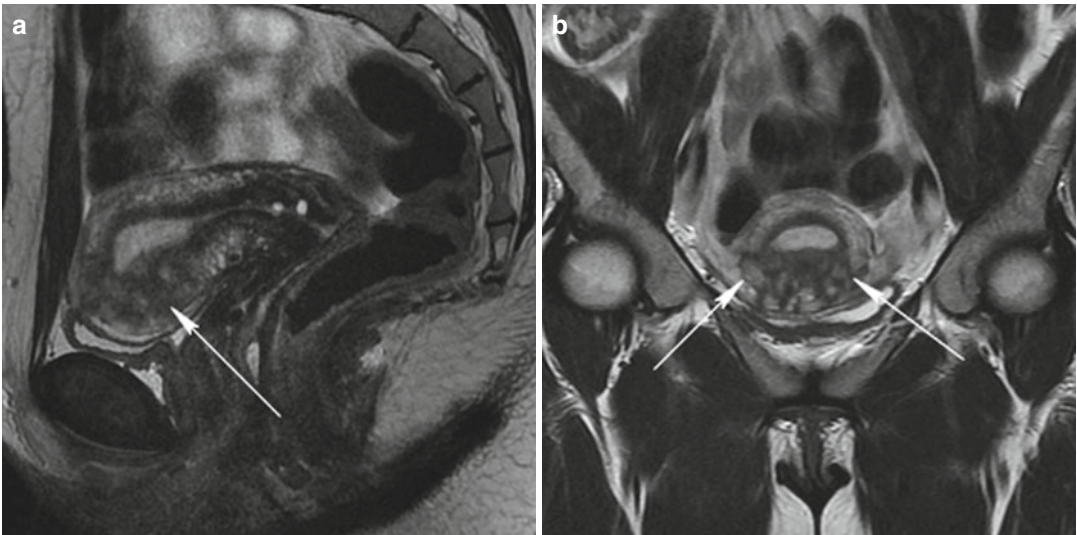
Adenomyosis. Sagittal (TR 4,500 ms, TE 90 ms) (a) and coronal (TR 4,300 ms, TE 110 ms) (b) T2-weighted images show an ill-defined low-signal-intensity area in the inferior uterine region, with several
